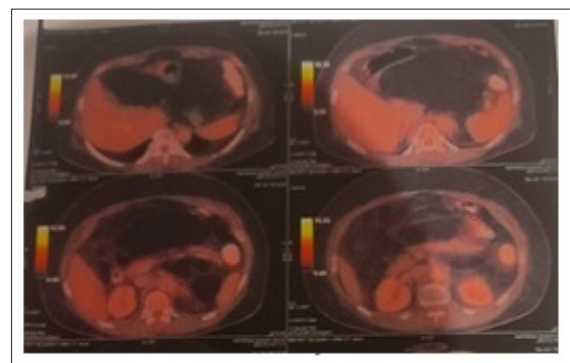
Pet CT image Showing Tumour Involving Entire Upper Abdomen without FDG Activity.
